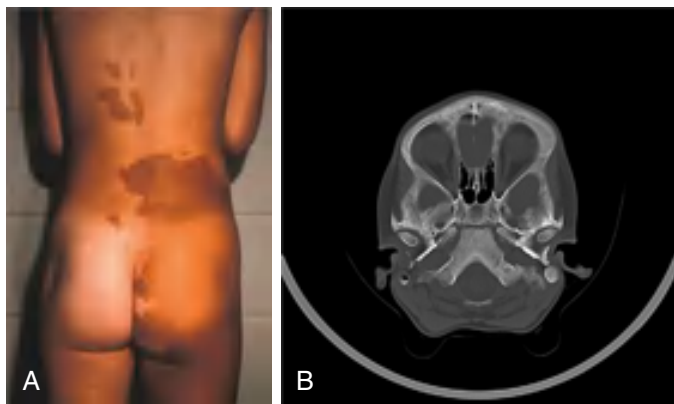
Precocious puberty with McCune-Albright syndrome (MAS). A, A girl presented at 5 yr of age with early stage III breast development and vaginal bleeding. Note the extensive café-au-lait skin patches, some of which did not cross the midline. B, A girl presented with recurring episodes of mild breast enlargement and vaginal bleeding associated with ovarian cysts, starting at age 7 mo. She had no skin lesions and a negative skeletal survey and bone scan at age 4 yr. The diagnosis of MAS was established at 5 yr of age, when prominence of her left forehead and supraorbital ridge prompted a CT scan, which revealed unilateral thickening of the skull bones (B). Skull lesions are often hyperostotic, whereas long bone lesions usually have a lytic, “ground-glass” appearance.
